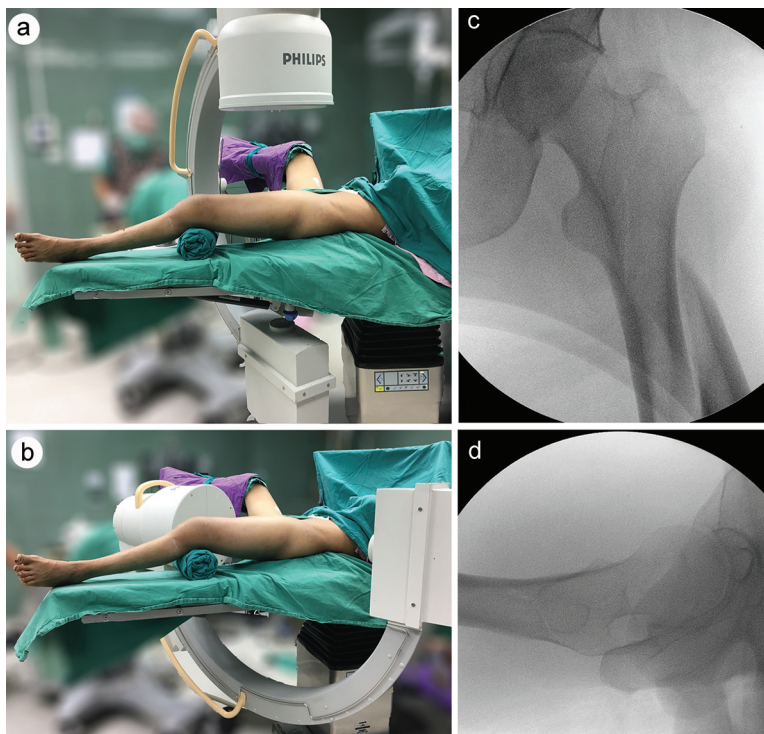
Preoperative positioning for reverse contralateral distal femoral locking compression plating of a subtrochanteric femoral fracture. (a, b) The patient was prepared in the hemi-lithotomy position with popliteal support and verified through intraoperative imaging. (c, d) Intraoperative true anteroposterior and lateral radiographs of the proximal femur.
